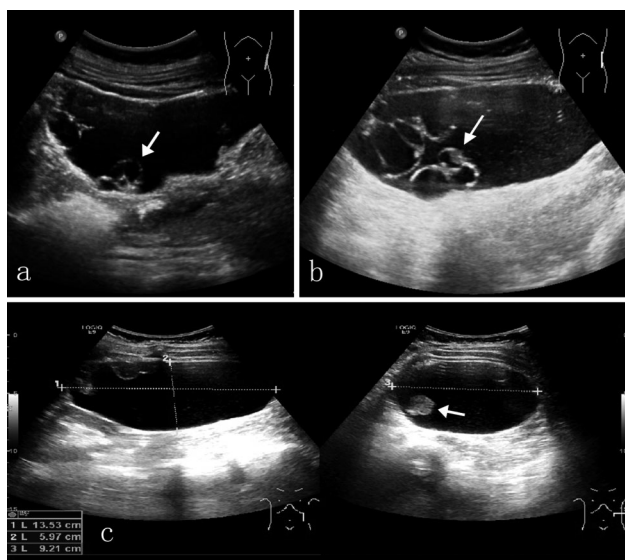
(a) Ultrasound imaging 1.5 months after drainage showing the cystic mass with clear cystic fluid and some thin septation (white arrow) in it. (b) Ultrasound imaging when the woman was eight months' pregnant showing unevenly thickened septation (white arrow) and turbid cystic fluid. (c) Ultrasound imaging seven months after the delivery showing the cystic mass with fused septation presenting a nodular appearance and enlarged papillary nodules (white arrow) on the septation and cystic wall. The cystic fluid is clearer with less debris floating in it.
